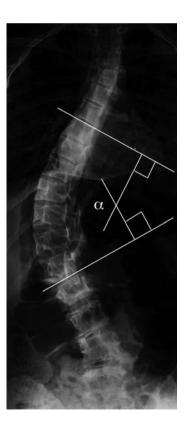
Cobb angle (α) measurement on a standard anterior–posterior view spinal radiograph
